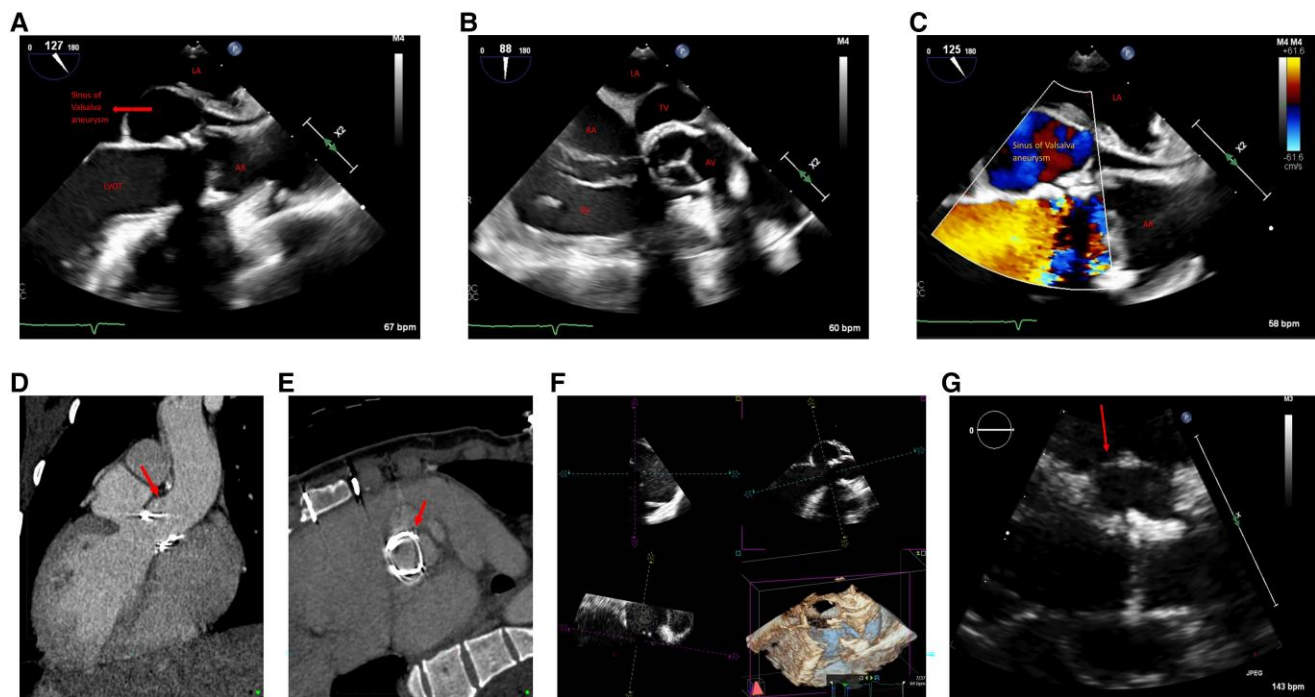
(A) Mid-oesophageal long-axis view looking at aortic valve, sinus of Valsalva aneurysm, and left ventricle outflow tract. (B) Mid-oesophageal short-axis view looking at the aortic valve with aneurysmal dilatation of the sinus of Valsalva. (C) Closer view of the mid-oesophageal view with colour flow Doppler looking at aortic valve, aortic root, and aneurysm of the sinus of Valsalva. (D) Re-constructed computed tomography image replicating the transoesophageal echocardiogram long axis view showing the left ventricle, aortic root, and ascending aorta. Arrow indicating the sinus of Valsalva aneurysm. (E) Re-constructed computed tomography image replicating the transoesophageal echocardiogram short axis view with arrow indicating the prosthetic aortic valve and sinus of Valsalva aneurysm. (F) Three-dimensional echo with multi-planar re-construction demonstrating the sinus of Valsalva aneurysm. (G) Transthoracic echocardiogram parasternal long-axis view with arrow indicating the sinus of Valsalva aneurysm.
